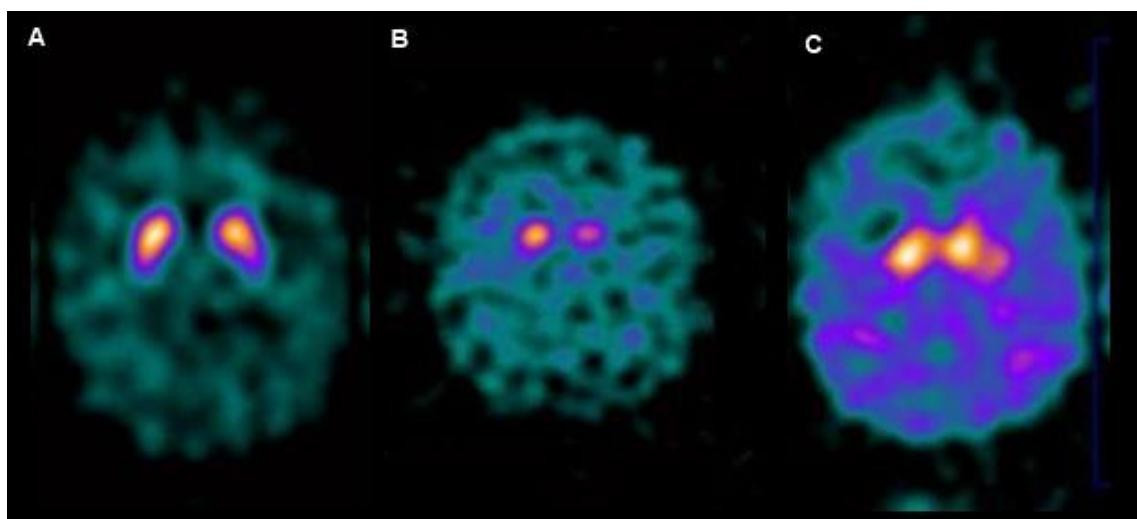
Estudios SPECT [^{123}I]-loflupano.
